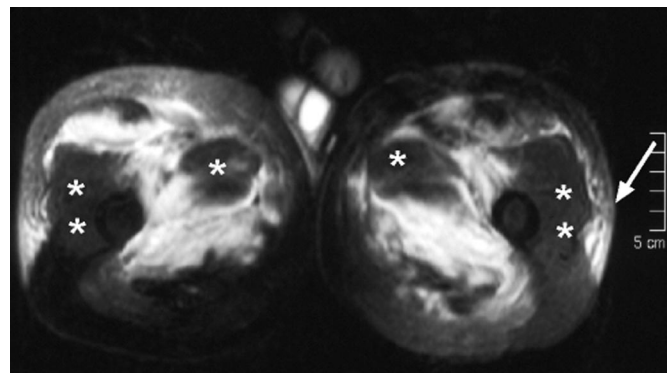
Axial T2-weighted fat-suppressed MRI of the proximal thighs. The high signal areas represent muscle and subcutaneous edema. The adductor longus () and vastus lateralis (*) muscles were spared. The focal disruption of the subcutaneous tissue laterally (arrow) overlying the vastus lateralis muscle corresponds to the track of the percutaneous muscle biopsy.*
